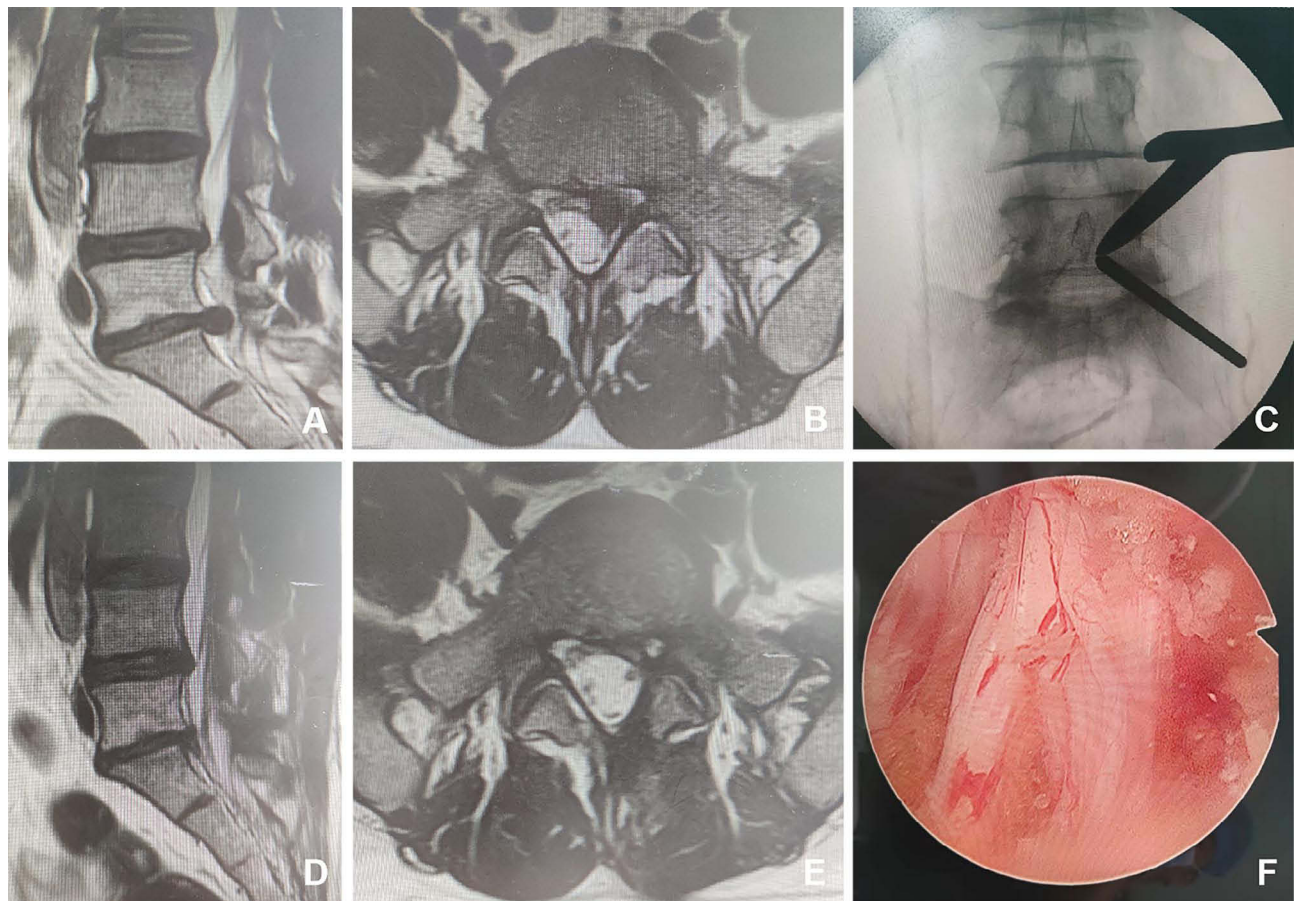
Male, 34 years old, L5/S1 lumbar disc herniation. (A) Preoperative sagittal MR image showed L5/S1 lumbar disc herniation; (B) Preoperative axial MR image showed herniated lumbar disc compressed nerve root and dural sac; (C) Intraoperative fluoroscopic confirmation of metal rods; (D) Postoperative sagittal MR image revealed the complete decompression of the spinal canal; (E) Postoperative axial MR image showed the complete removal of herniated disc and bony fragment; (F) Intraoperative image after complete neural decompression.
